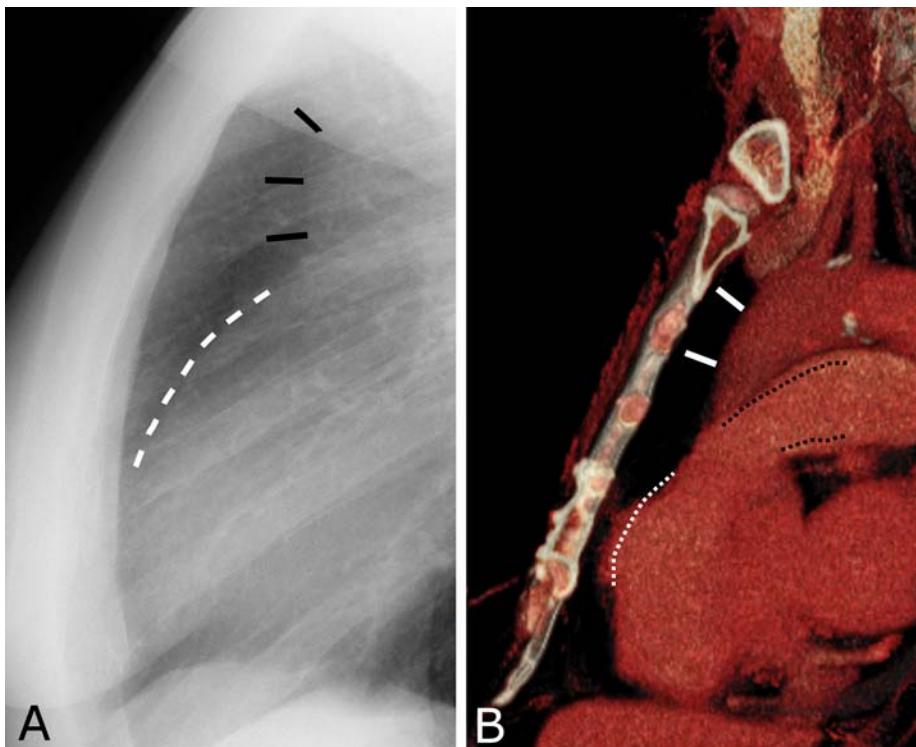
Anterior mediastinal border. A. Lateral radiograph shows the anterior margin of the heart, which is formed by the right ventricle (white dashes). The structure arching superiorly (black lines) is the ascending aorta. B. Volume rendered CT image showing the anterior mediastinal anatomy as it is seen on a lateral radiograph. The right ventricle (RV) is the anterior border. The ascending aorta (white lines) is also seen, though usually not as well. The main pulmonary artery (black dots) is not surrounded by air at this level and thus is not seen on the lateral radiograph.
